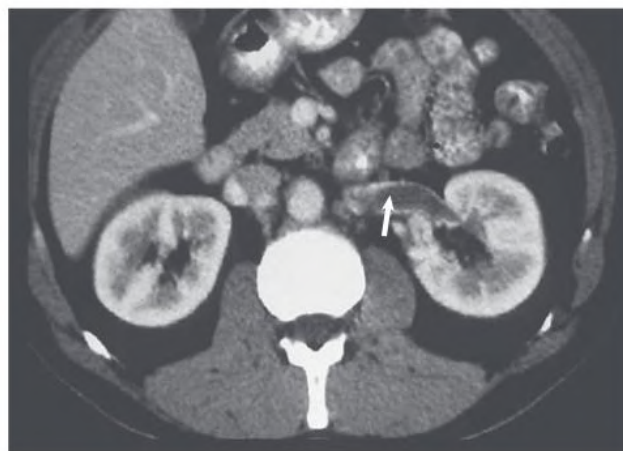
Computed tomography venogram demonstrating left renal vein thrombosis (arrow). (Courtesy Dr. S. Rankin, Guy's Hospital, London.)
